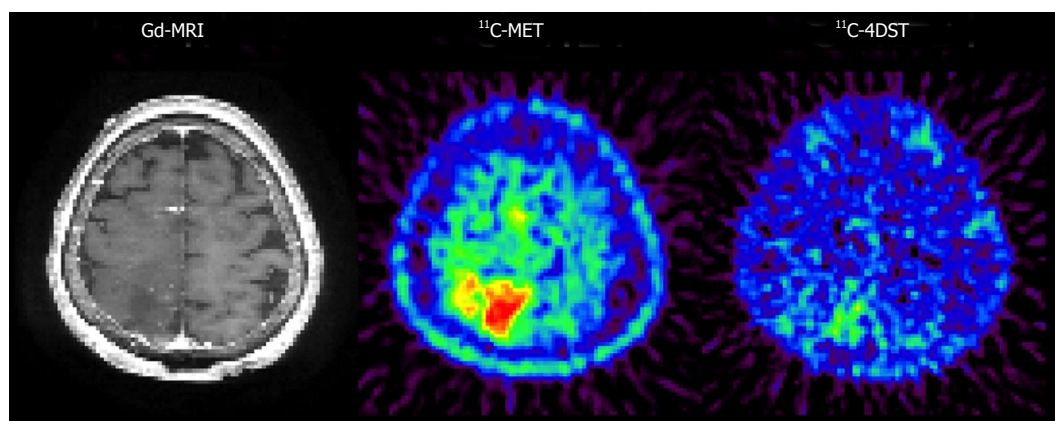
4'-[methyl- ^{11}C]-thiothymidine uptake in oligodendroglioma. A patient was diagnosed with grade 2 astrocytoma during the initial operation. At the 1-year follow-up, an enhanced lesion appeared on MRI and ^{11}C -MET uptake increased around the initially resected lesion. These findings suggested that the malignant transformation of astrocytoma occurred. However, ^{11}C -4DST uptake into the tumor was not different from basal brain levels. The pathological diagnosis at the second operation was grade 2 oligodendroglioma with a newly appearing oligodendroglioma component, but without malignant transformation. Reprinted from Nariai *et al*^[14], with the permission of Springer. ^{11}C -4DST: 4'-[methyl- ^{11}C]-thiothymidine; ^{11}C -MET: ^{11}C -Methionine; Gd-MRI: Gadolinium-enhanced magnetic resonance image.
